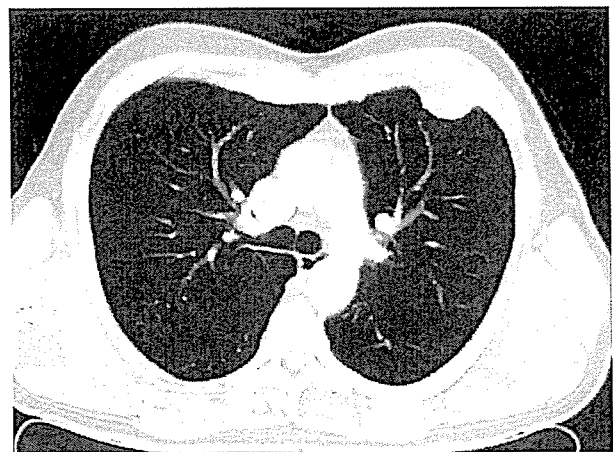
Computed tomographic scan showing chest wall mass at anterior ends of the third to fifth ribs.
